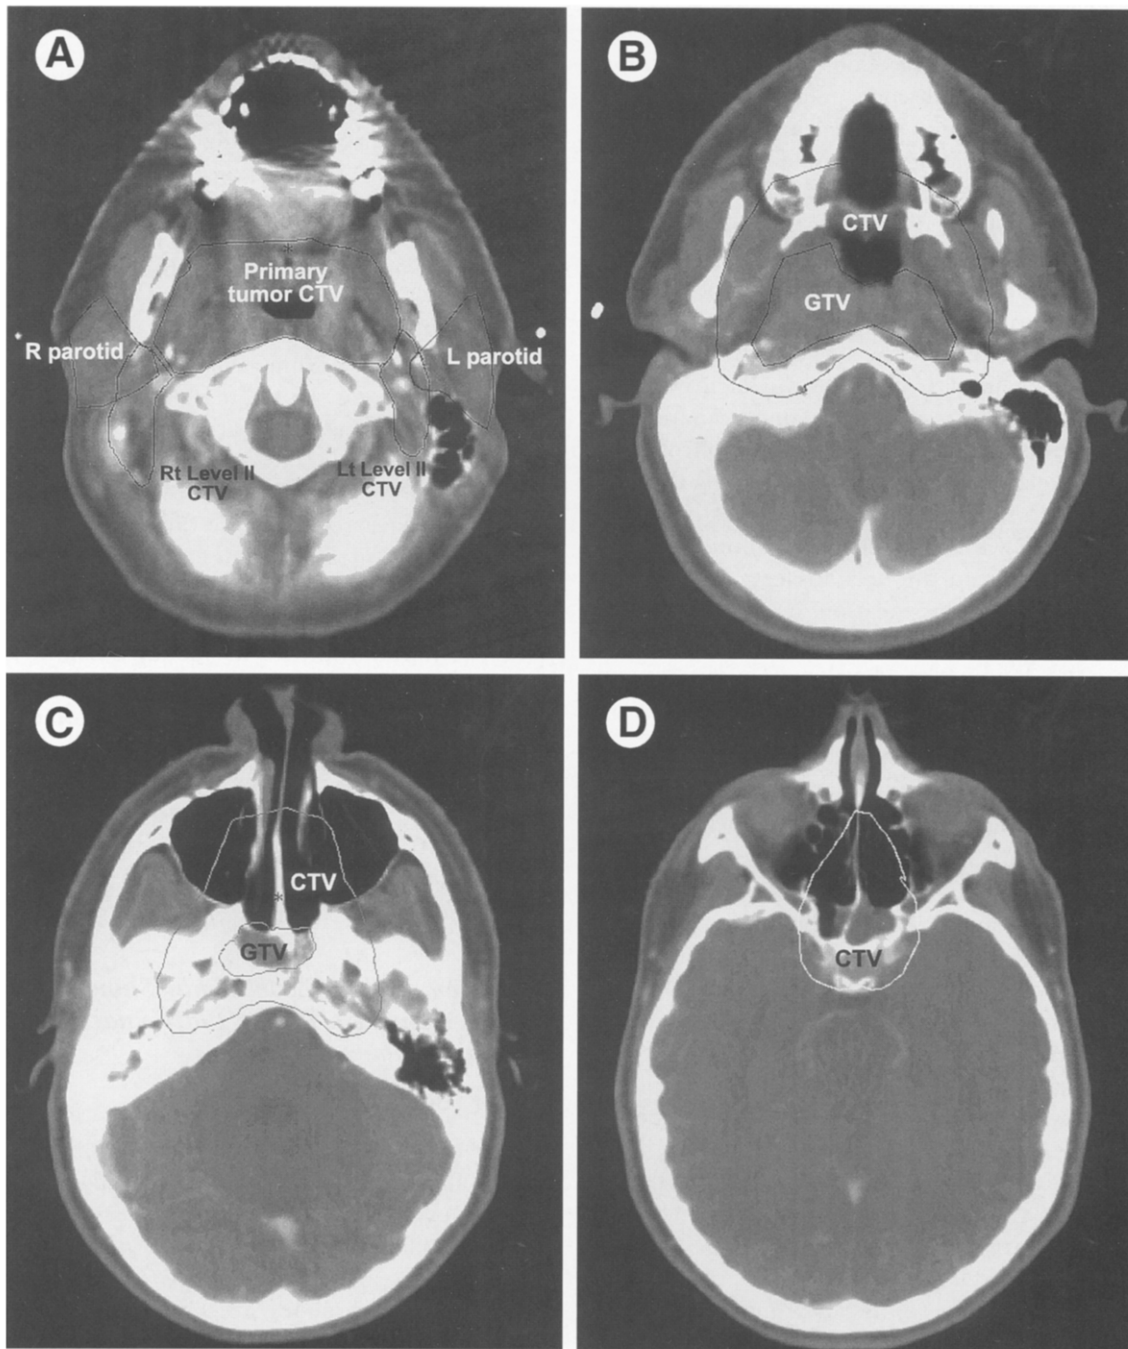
Delineation of the primary tumor GTV and CTV, and upper Level II CTVs, in a case of nasopharyngeal cancer, tumor stage T3. The GTV was delineated on MRI and the contours were registered with the planning CT. For treatment planning, the GTV and CTV were each expanded uniformly by 5 mm to yield the corresponding PTVs. (A) Caudal to the nasopharynx: The pharyngeal walls and parapharyngeal spaces constitute the primary tumor CTV. Level II CTVs are delineated to the base of skull bilaterally. (B-C) The clivus, foramina at the base of skull, pterygoid plates, posterior maxillary sinuses, and nasal cavity are encompassed by the CTV. (D) Cranial to the MRI-defined GTV, the sphenoid and cavernous sinuses are encompassed by the CTV.
